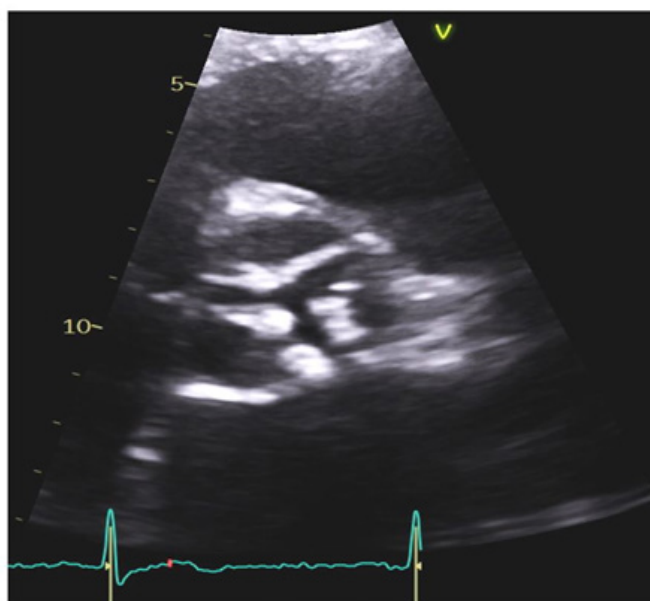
Transthoracic echocardiography showing aortic valve in parasternal short axis view.
